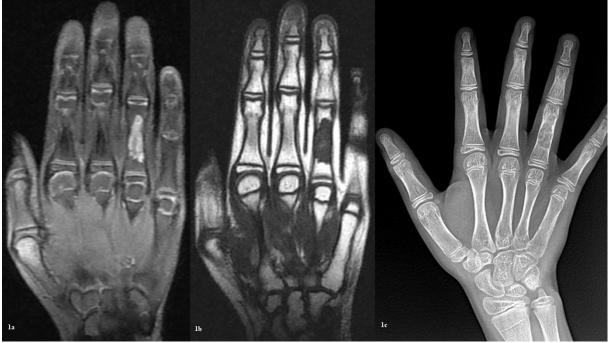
MRI and X-ray samples of a patient with enchondroma in the fourth metacarpal 1a: MRI T2 sequence image 1b: MRI T1 sequence image 1c: X-Ray image
